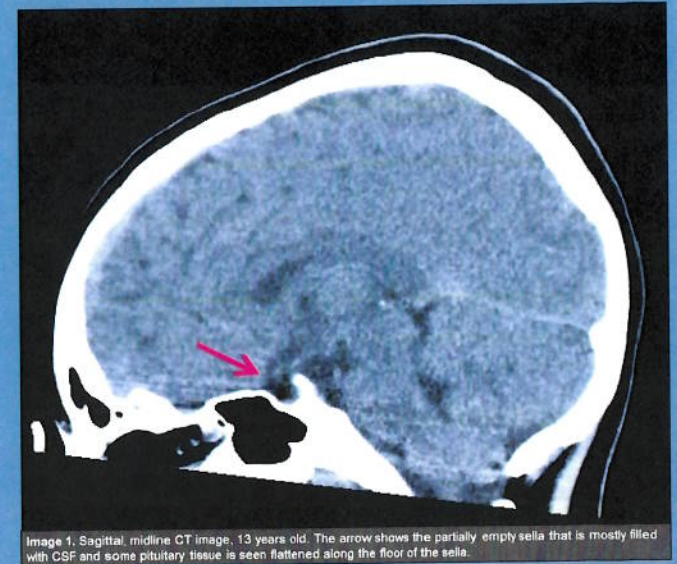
Sagittal, midline CT image, 13 years old. The arrow shows the partially empty sella that is mostly filled with CSF and some flattened pituitary tissue is seen flattened along the floor of the sella.
